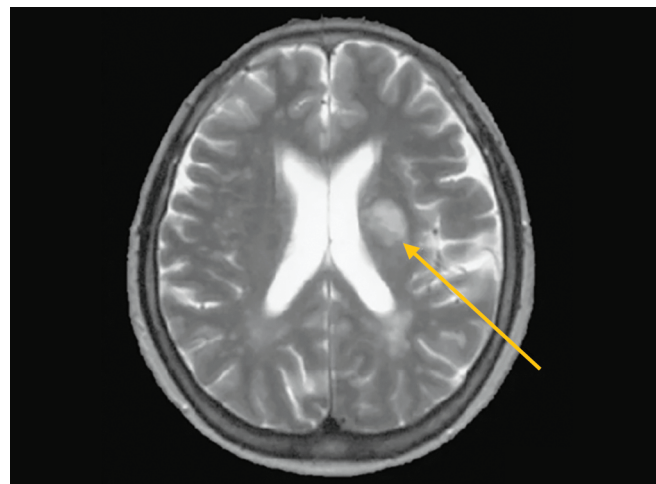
Axial T2 weighted MRI showing infarct in left corona radiata
